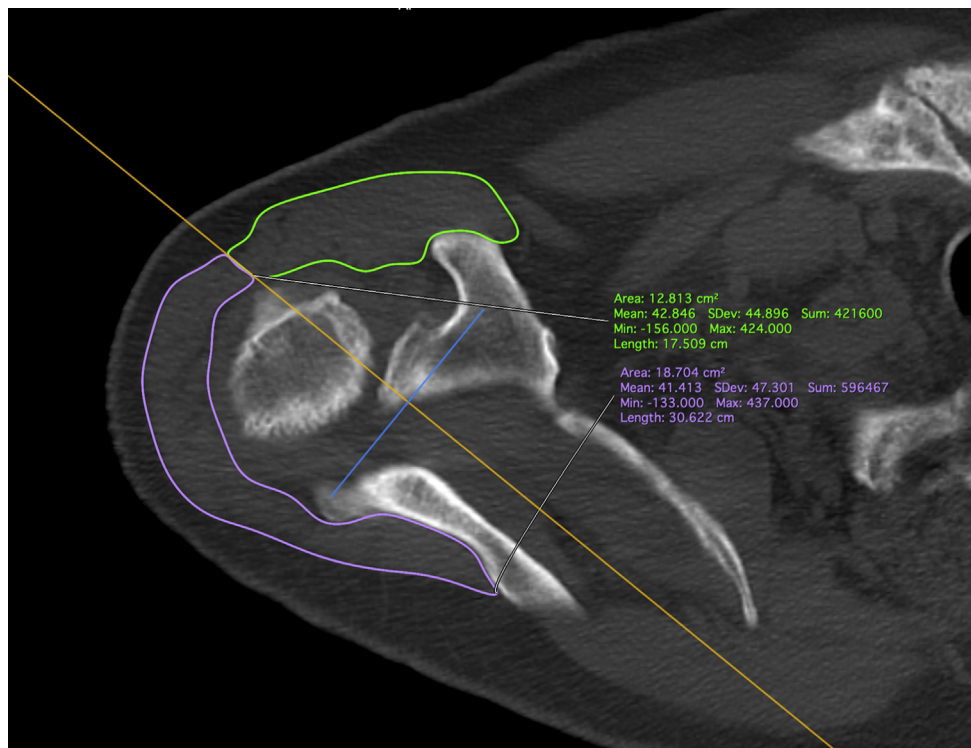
Depiction of deltoid muscle area measurement. Shown is a right shoulder computed tomography (CT) scan with outlined anterior and posterior deltoid area measurements (Horos, Purview, Annapolis, MD, USA).
